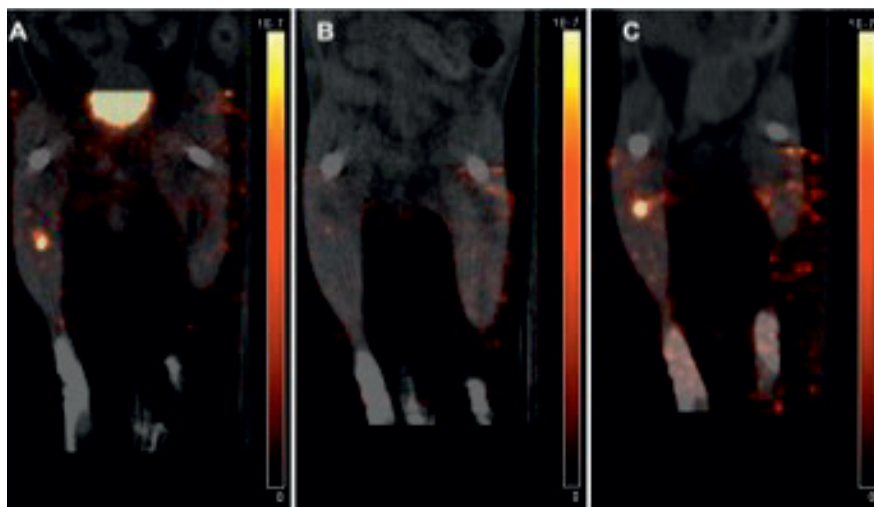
SPECT imaging of islet transplants with ^{111}In -exendin.
